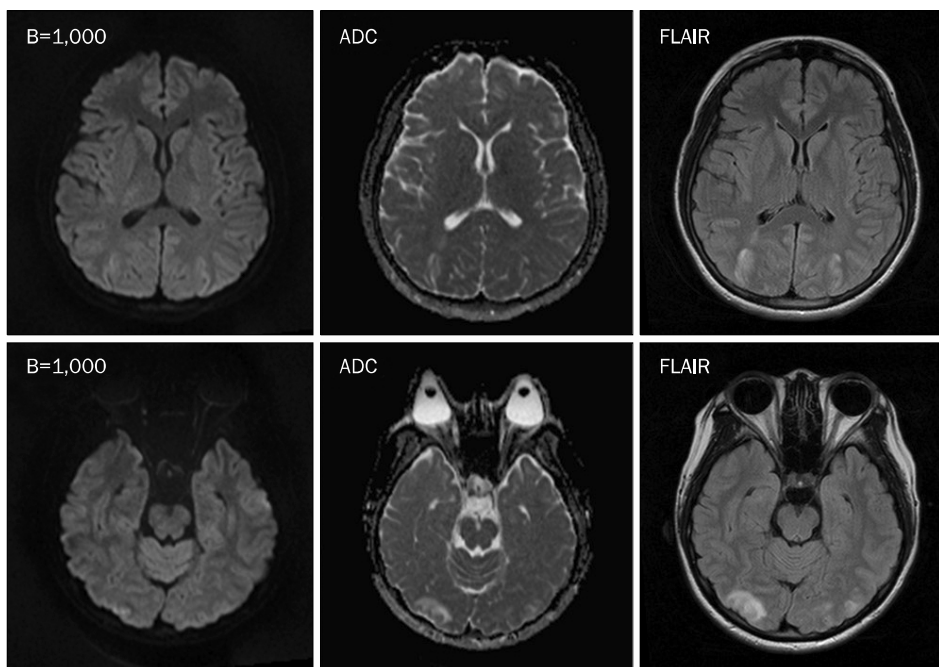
The brain MRI showed high signal intensity in temporal, parietal, and occipital area. B value, diffusion gradient strength; ADC, apparent diffusion coefficient; FLAIR, fluid attenuated inversion recovery.
